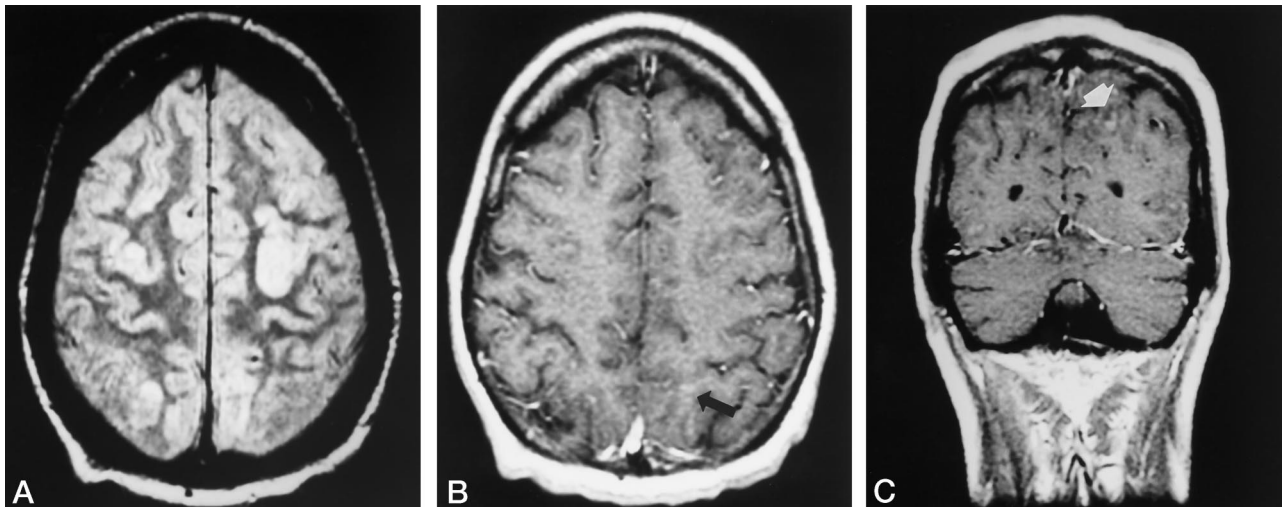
Patient 5. At 37 days after transplantation, proton density-weighted (2700/17/2) image shows bifrontal/biparietal hyperintense signal abnormalities, and contrast-enhanced axial (B) and coronal (C) T1-weighted (500/19/1) images show sulcal effacement and subtle parietal enhancement (arrow), best seen on the coronal image. At 54 days after transplantation, proton density-weighted image (D) shows residual gyri-form abnormality, and axial T1-weighted image (E) shows decrease in sulcal effacement and resolution of cortical enhancement.
